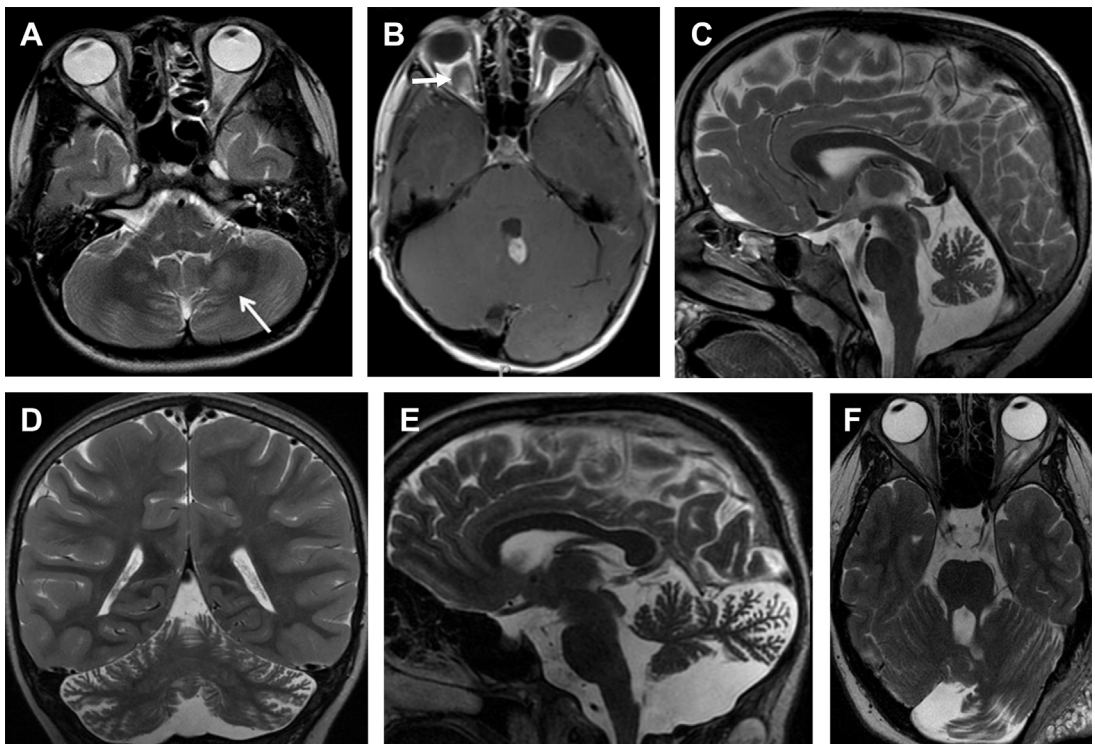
Neurofibromatosis type 1. (A) Axial T2-weighted image showing cerebellar parenchymal T2-hyperintense lesions (arrow), also referred to as unidentified bright objects. (B) Axial T1 postcontrast image demonstrating an enhancing glioma in the rostral and medial aspect of the cerebellar vermis and optic glioma on the left (arrow). (C) Sagittal and (D) coronal T2-weighted images showing normal size of the cerebellar vermis and hemispheres with stable enlargement of the interfoliar spaces consistent with cerebellar hypoplasia. (E) Sagittal and (F) axial T2-weighted images showing enlargement of the left cerebellar hemisphere. The posteromedial part of the left cerebellar hemisphere is bulky, crosses the midline, and its interfoliar spaces are enlarged, consistent with cerebellar dysmorphia. (From Toelle SP, Poretti A, Weber P, et al. Cerebellar hypoplasia and dysmorphia in neurofibromatosis type 1. *Cerebellum* 2015;14(6):642–9; with permission.)
